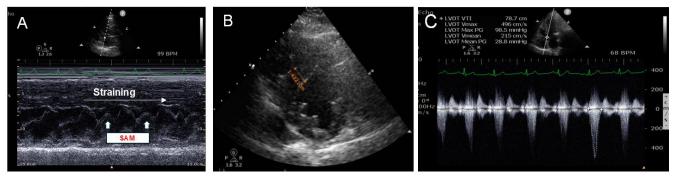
Transthoracic Echocardiogram. A) M-mode on MV leaflets showing significant SAM during Valsalva (arrowheads). B) Short axis on left ventricle, showing asymmetrical septal hypertrophy. C) CW Doppler on LVOT during Valsalva, showing significant obstruction with a peak gradient of 98 mmHg.
